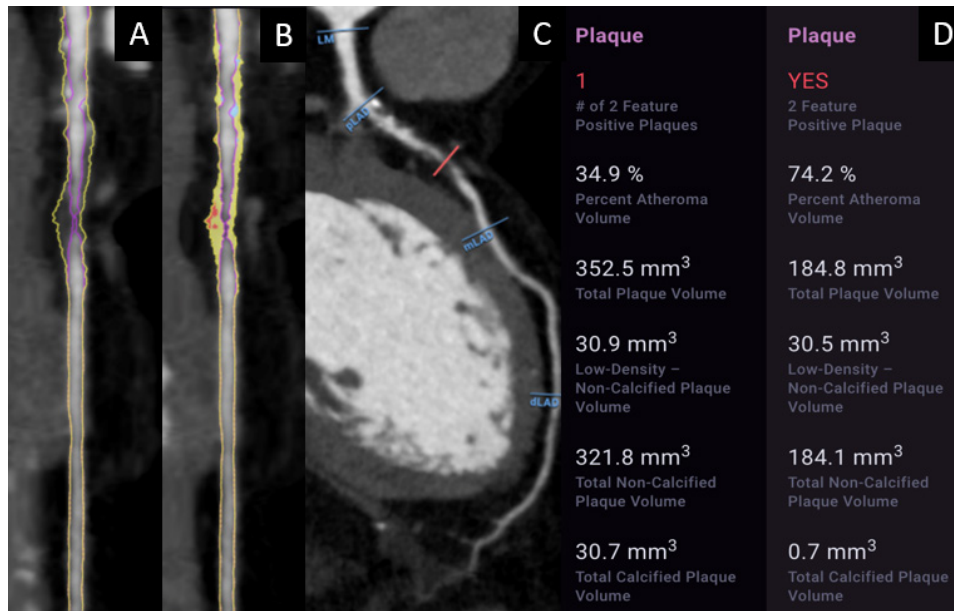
A 39-year-old with coronary CT angiography (CCTA) undergoing artificial intelligence (AI)-aided evaluation of stenosis and quantitative atherosclerosis burden. The patient demonstrates left anterior descending coronary artery obstructive stenosis (82%) with a burden of plaque (352.5 mm³) consisting predominantly of non-calcified (321.8 mm³) that includes low-density non-calcified plaque (LD-NCP 30.5 mm³). (A) shows a CCTA straight reformat with plaque identified, while (B) shows a straight reformat with a colour overlay of non-calcified plaque (yellow), LD-NCP (red) and calcified plaque (blue). (C) shows a curved multiplanar reformat. (D) shows a graphical output of the quantified plaque volume by AI-aided evaluation. dLAD, distal left anterior descending; LM, left main; mLAD, mid left anterior descending; pLAD, proximal left anterior descending.
